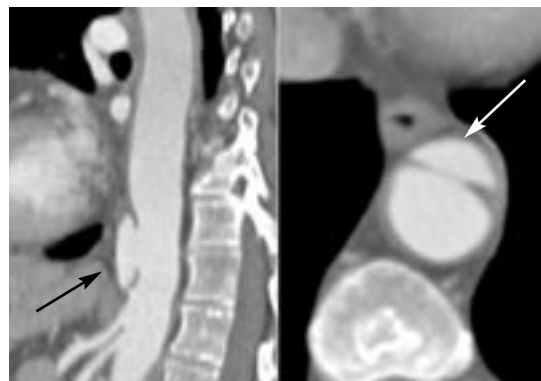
Coronal reformatted image (left) and axial image (right) from contrast-enhanced, cardiac-gated CT in a patient with acute aortic syndrome demonstrate a focal contrast-filled outpouching of the distal thoracic aorta consistent with a penetrating atherosclerotic ulcer (arrows).
